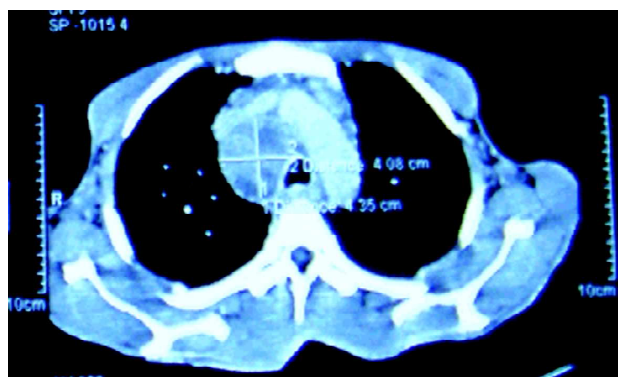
Contrast-enhanced computed tomography of chest showing conglomerated necrotic mediastinal lymph node mass.
